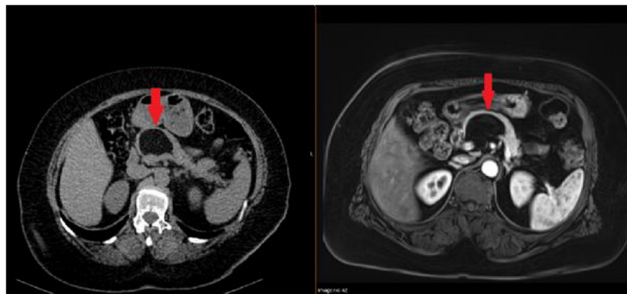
Computed tomography and MRI.
